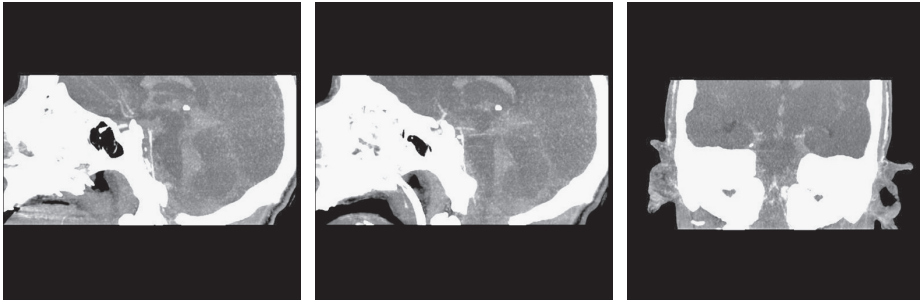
re-editing by neuroradiologist of CT scan done at the Bellinzona's Hospital; the specialist indicated us the probable point of vertebral artery laceration.
